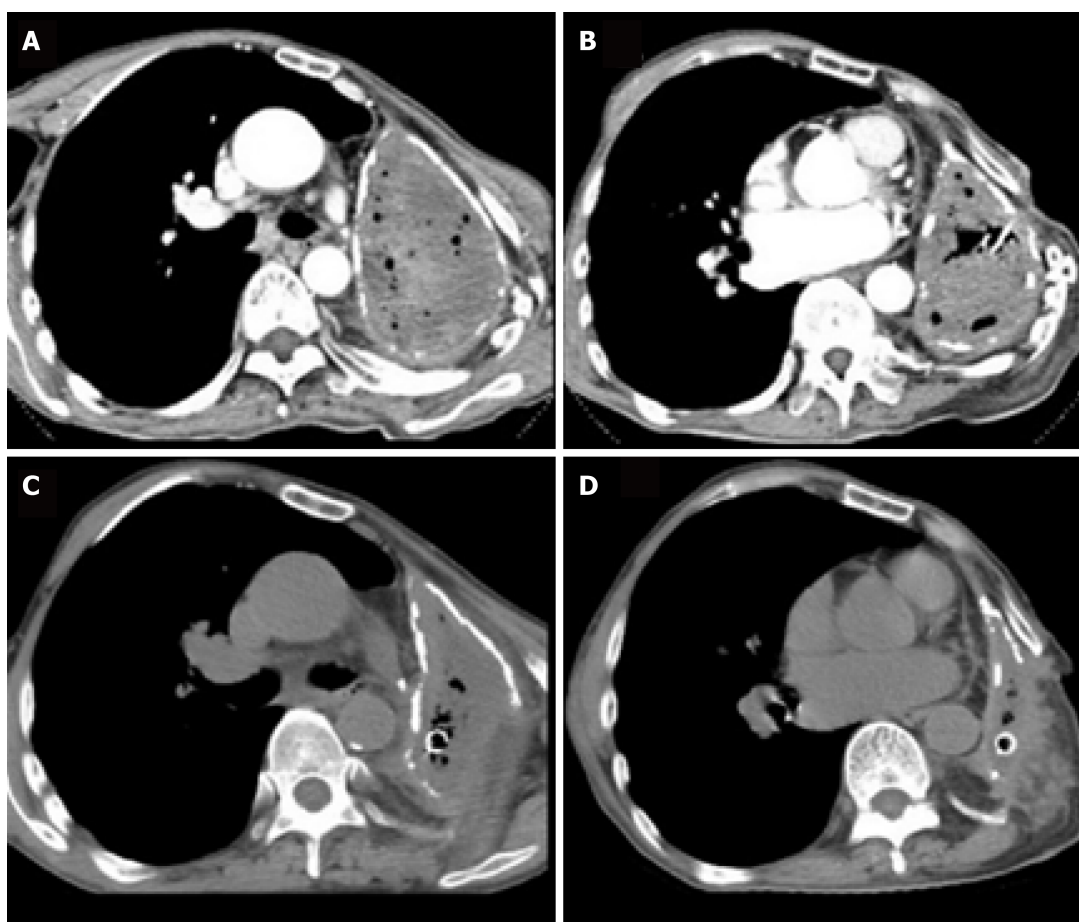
Chest computed tomography scan. A and B: Preoperative chest computed tomography (CT) scan (axial view) revealed complete opacification of the left contracted chest; C and D: Postoperative chest CT scan (axial view) showed that the pleural volume was reduced by half at two months after limited thoracoplasty.
